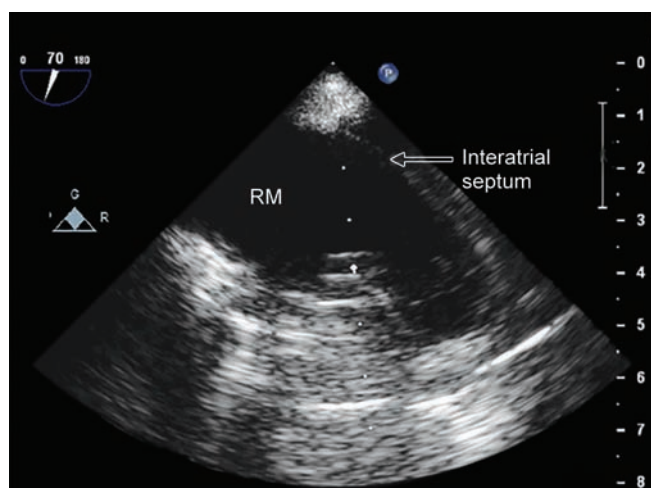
No residual thrombus is seen in right atrium on transesophageal echocardiography after retrieval of thrombus on cardiopulmonary bypass
